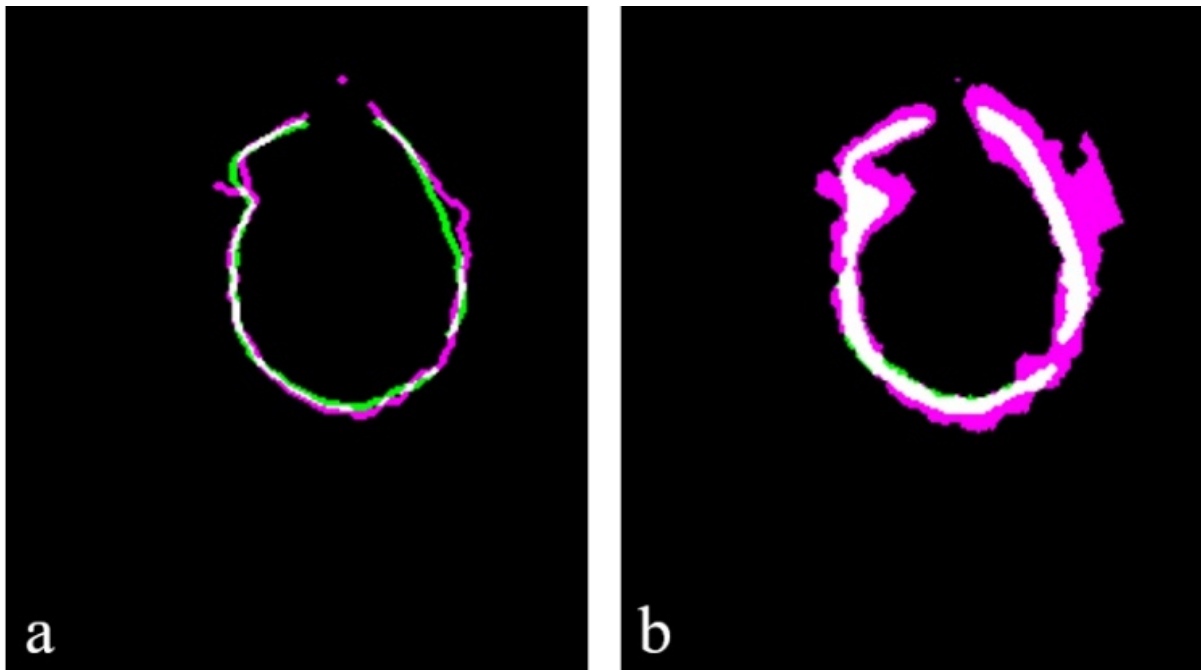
Overlaid segmentations of static silicone valve TEE (pink) and CT (green) images, and complete agreement between them (white) a) with centre-line extraction from 3DCMF segmentation and b) with 3DCMF segmentation only
